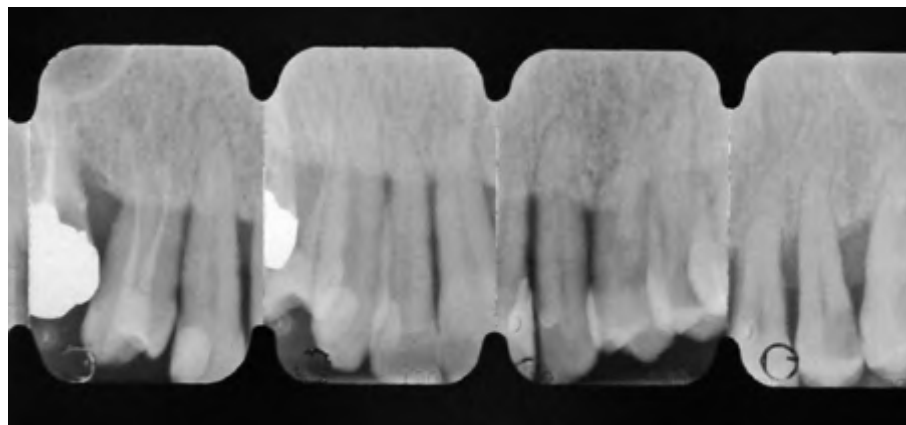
Preoperative periapical radiographs of the maxillary anterior quadrants.
